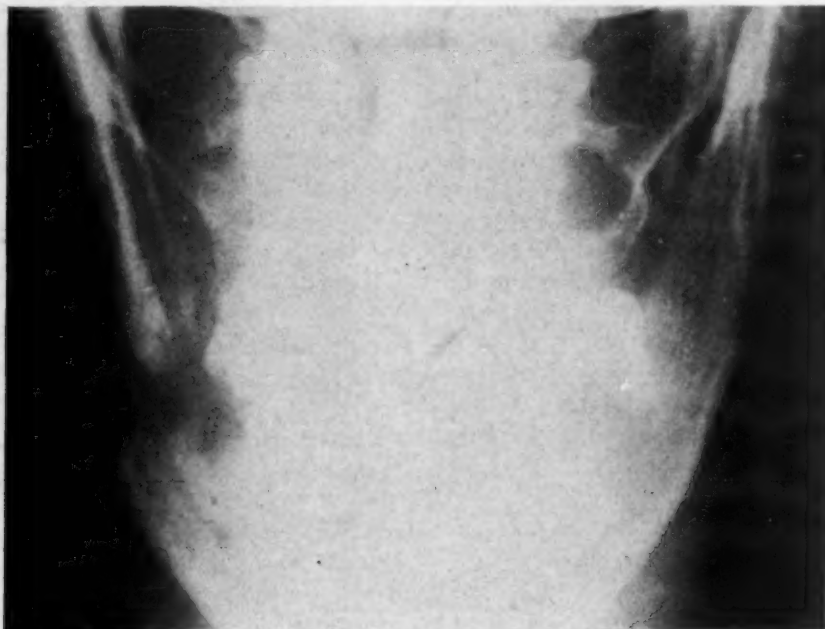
X-ray showing ununited mandibular fracture, anteroposterior view.
